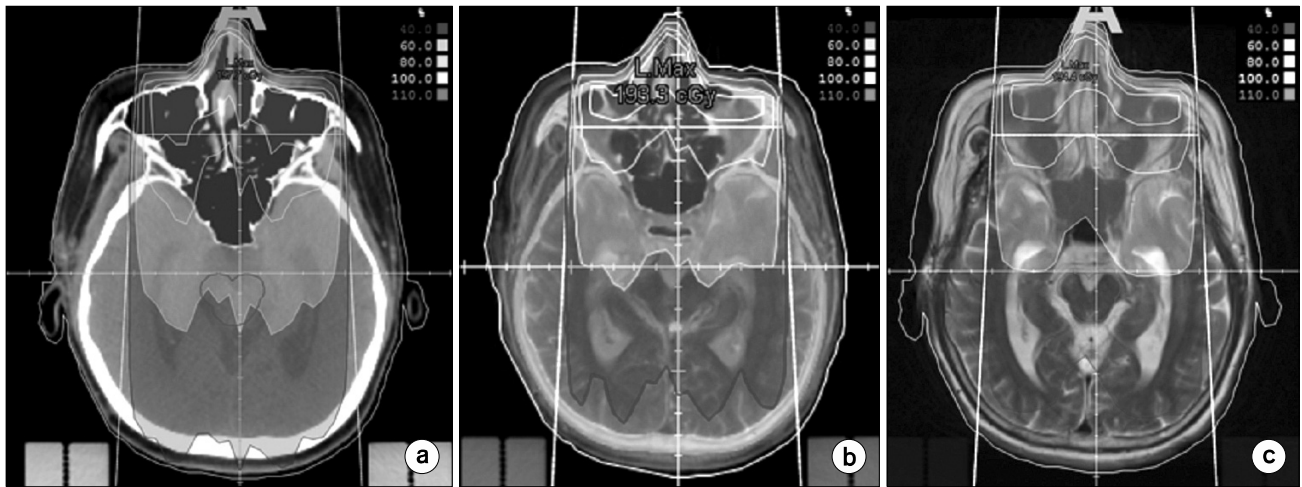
Dose distributions are shown on the CT image and MR images (a) CT-based isodose curve, (b) /MRI-based isodose curve, and (c) wMRI-based isodose curve.
